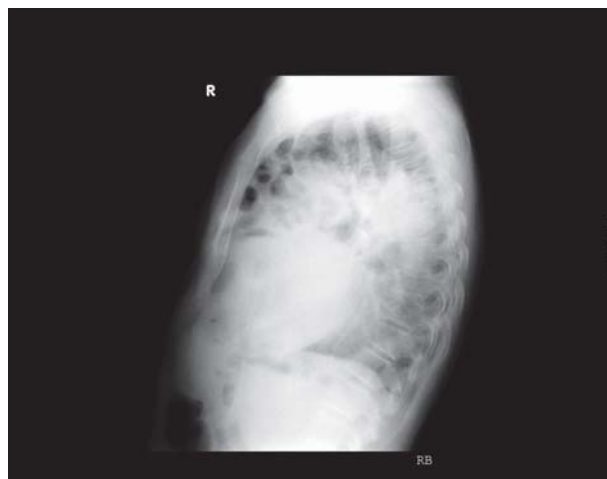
Chest radiograph (lateral view) showing an opacity with haustrations suggestive of bowel loops.
